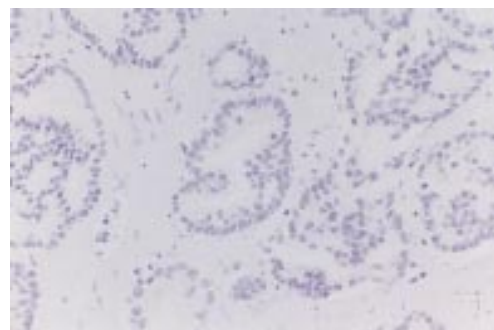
Absence of cyokeratin 8 expression in histomorphologically unaffected malignant epithelium within the high intensity focused ultrasound lesion. CAM5.2 antibody.
